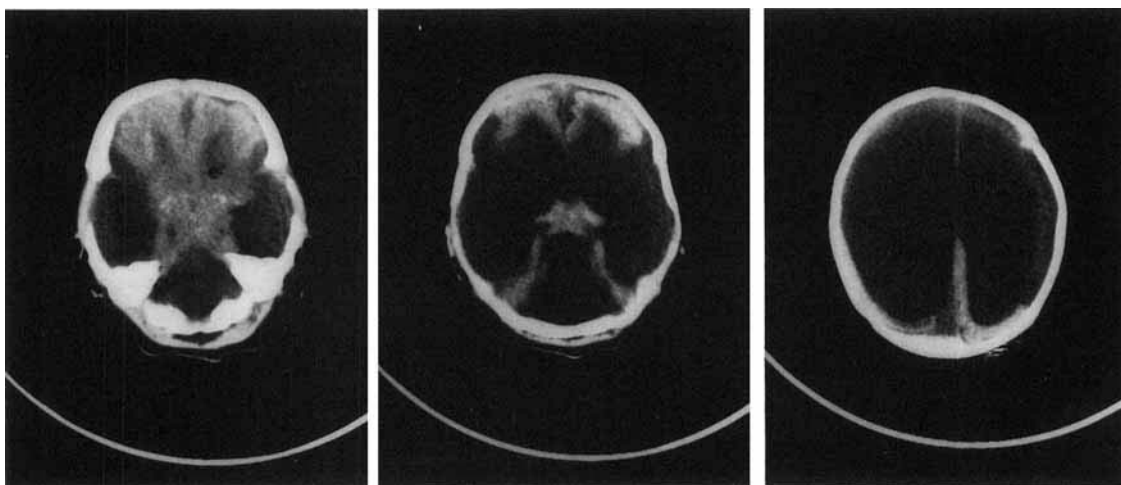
CT scan of the brain, patient 1. Note large bilateral hemispheric defects, enlarged ventricles, absence of the septum pellucidum, hypoplasia of the cerebellum with aplasia of the vermis, and cystic expansion of the posterior fossa.
